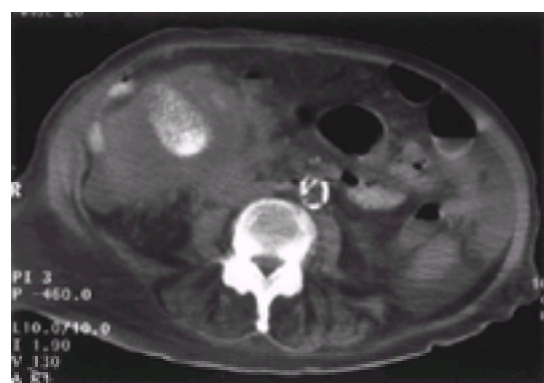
CT scan demonstrating a large gallbladder cancer with extension into the duodenum; gallstones (calcifications) are present within the mass.
